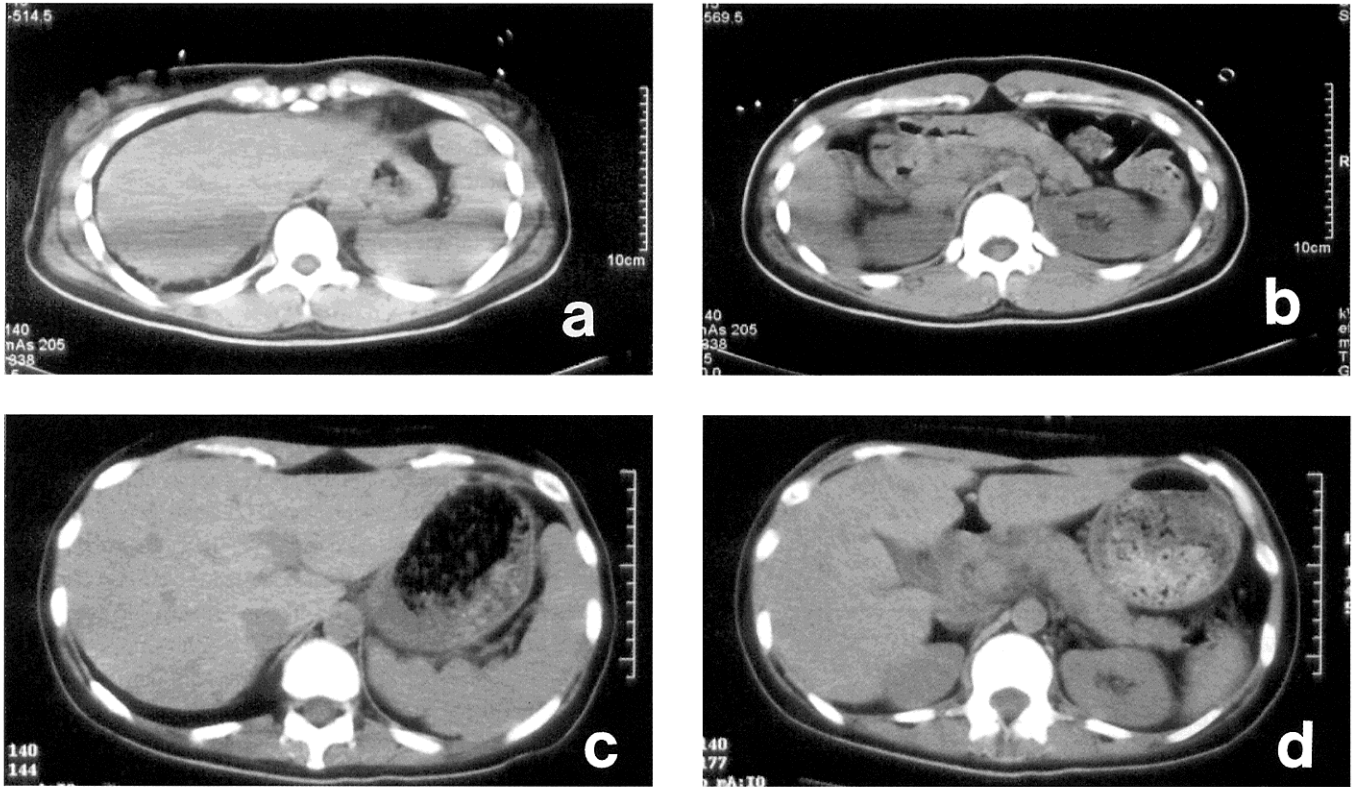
Abdominal computed tomography on July 3, 2003, showed liver atrophy (a, b), but liver atrophy gradually improved on September 5, 2003 (c, d).
